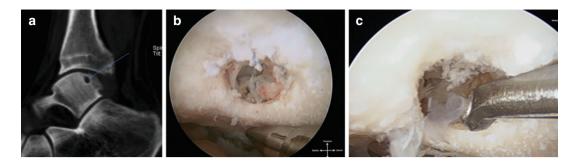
CT scan where a posterior talus cyst is visible (*blue arrow*) (\mathbf{a}); arthroscopic view of the cyst (\mathbf{b}) and debridement prior to bone grafting (\mathbf{c})
